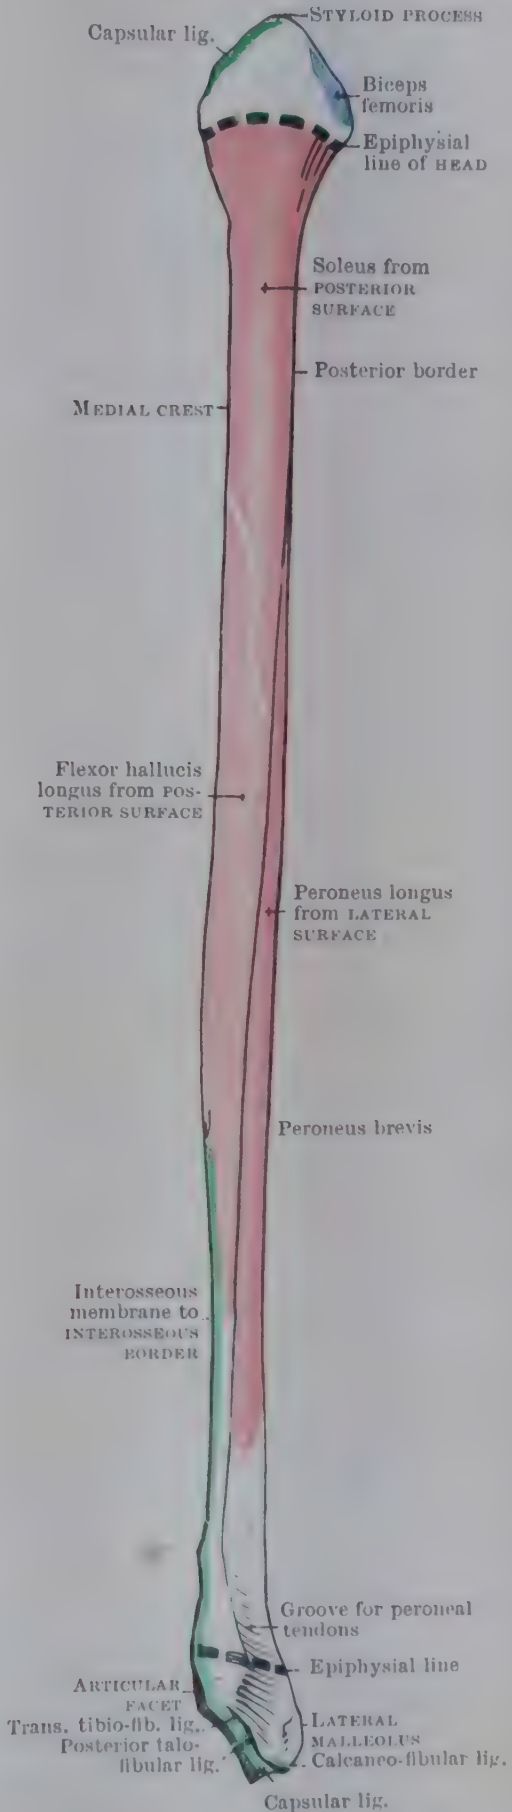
POSTERIOR ASPECT OF RIGHT FIBULA.
